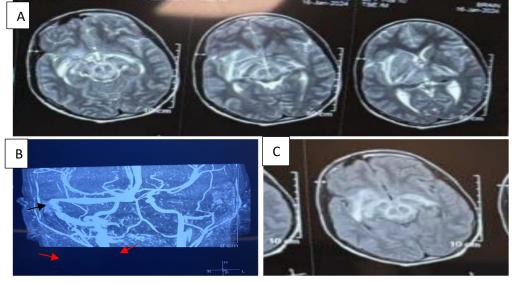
a and c denotes T2 WI/FLAIR showing hyperintensity in upper part of midbrain, posterior limb of bilateral internal capsule and thalami; b denotes Time-Of-Flight MRA showing Beaded appearance of P1 part of right PCA (marked with black arrow) and Beaded appearance of bilateral A1 part of ACA (marked with red arrow).
